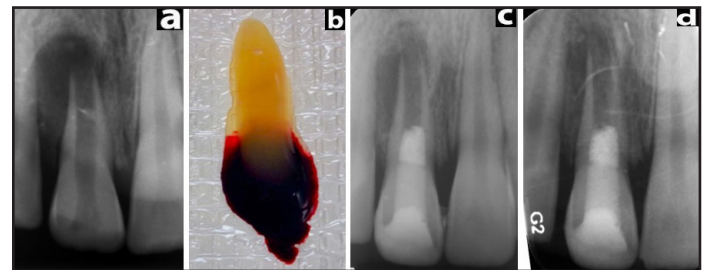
(a) Preoperative radiograph (b) PRF (c) Post-operative radiograph (d) Radiograph taken at 1-year of follow-up showing lesion
